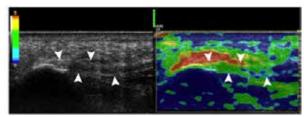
PA of a patient with pain on her left heel from the study by Lee et al. On the left B mode image, the arrowheads represent features of a normal PA. On the right ultrasound elastography image, the arrowheads and green areas represent softening of the PA. Adapted from Journal of Clinical Imaging.¹⁴
